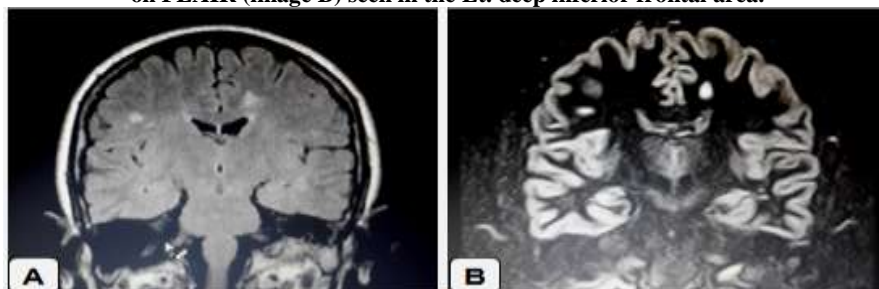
Shows the active white matter lesion seen by DIR (image B) was not detected by FLAIR (image A) in the Rt. upper parietal region. Notice also how elegantly the other 2 WM lesions are seen by DIR. Patient had multiple focal neurologic deficits.
